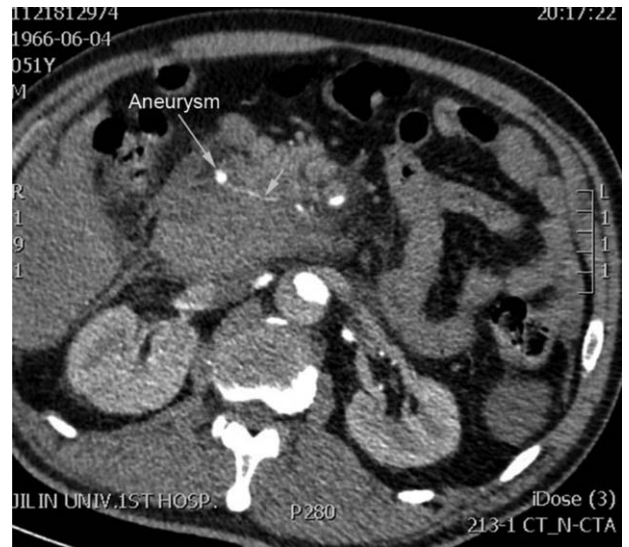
Thoracoabdominal CTA demonstrated aortic dissection involving SMA and retroperitoneal hemorrhage secondary to SMA branch pseudoaneurysm rupture. CTA = computed tomography angiography, SMA = superior mesenteric artery.
